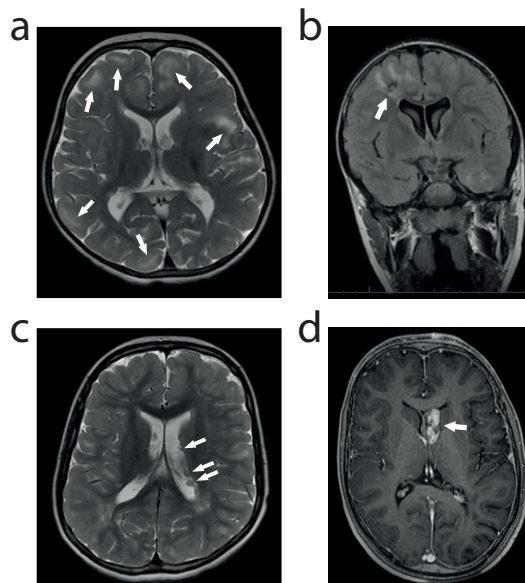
Brain MRI images of 4 patients with TSC. (A) Axial T2 weighted image. Cortical tubers are indicated by the white arrows. (B) Coronal FLAIR image. The white arrow indicates a RML. (C) Axial T2 weighted image. The arrows indicate three SENs in the lateral ventricle. (D) Axial T1 weighted image. The arrow indicates a SEGA in the lateral ventricle.
